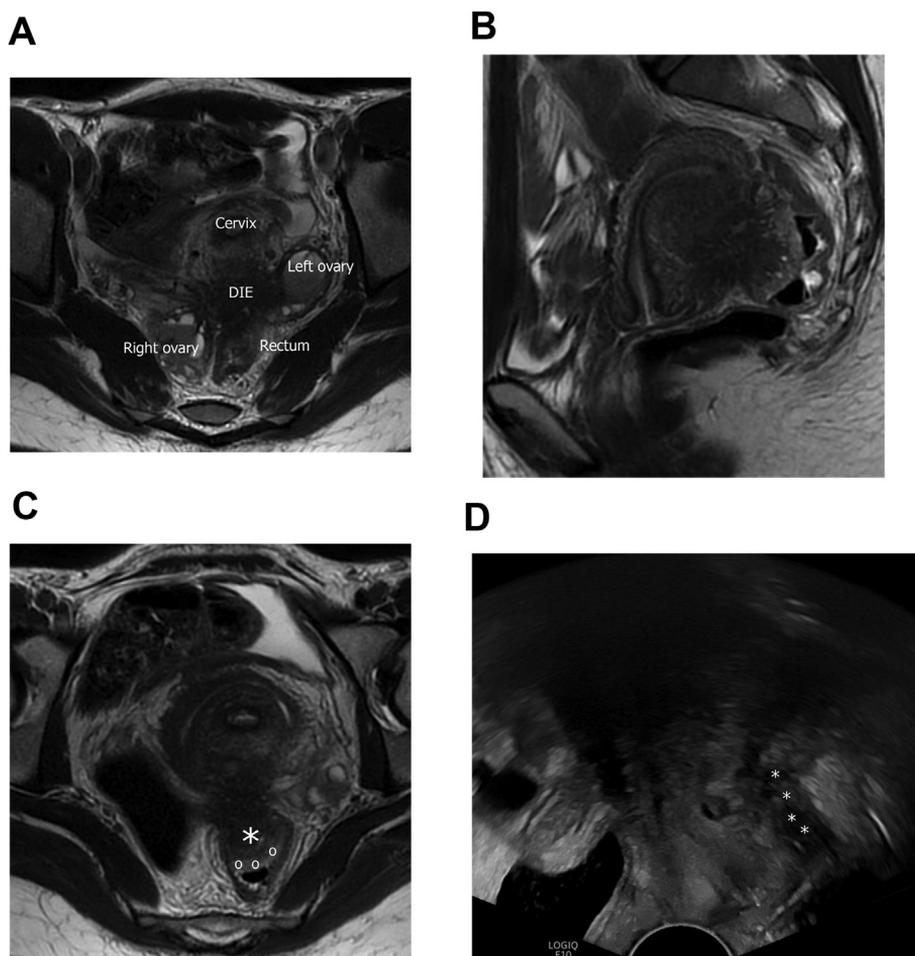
A 27-year-old patient with chronic pelvic pain. (a, c) Axial and (b) sagittal pelvis MRI 3D-T2W images show a DE (*) of the lower posterior compartment with a 50 mm length fan-shaped lesion of the mild and upper rectum at 9 cm from the anal verge on 20 mm depth and 90° of circumference. Note the presence of sub-mucosal edema (o) in keeping with its involvement characteristic of the mushroom cap sign (3b). At surgery, segmental resection performed.
